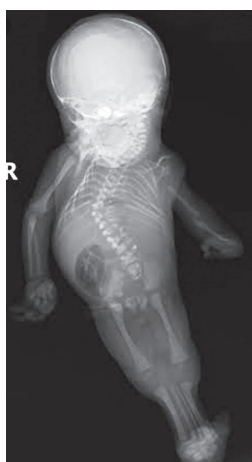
Showing Xray of the delivered baby.
